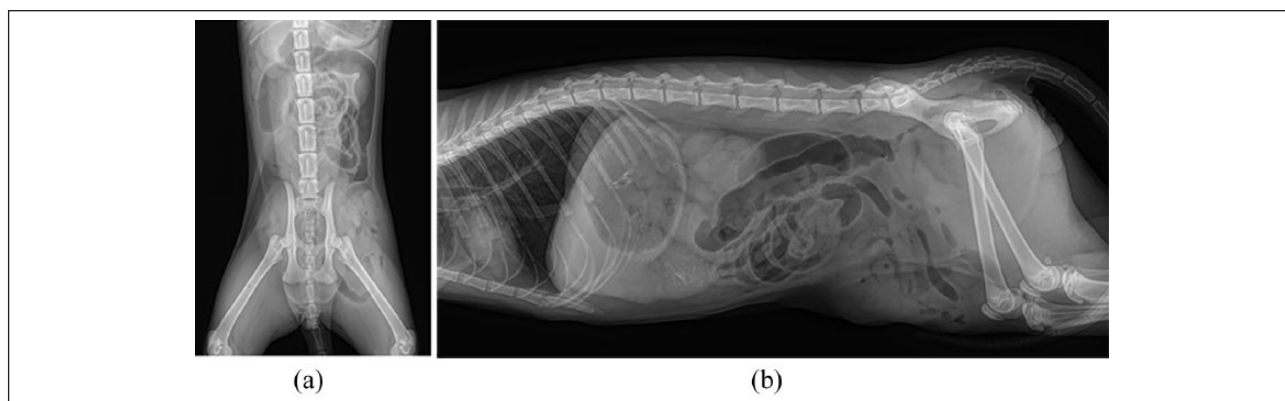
(a) Ventrodorsal radiograph obtained at the time of presentation showing inguinal herniation of the small intestines. (b) Right lateral radiograph obtained at the time of presentation showing inguinal herniation of the small intestines
